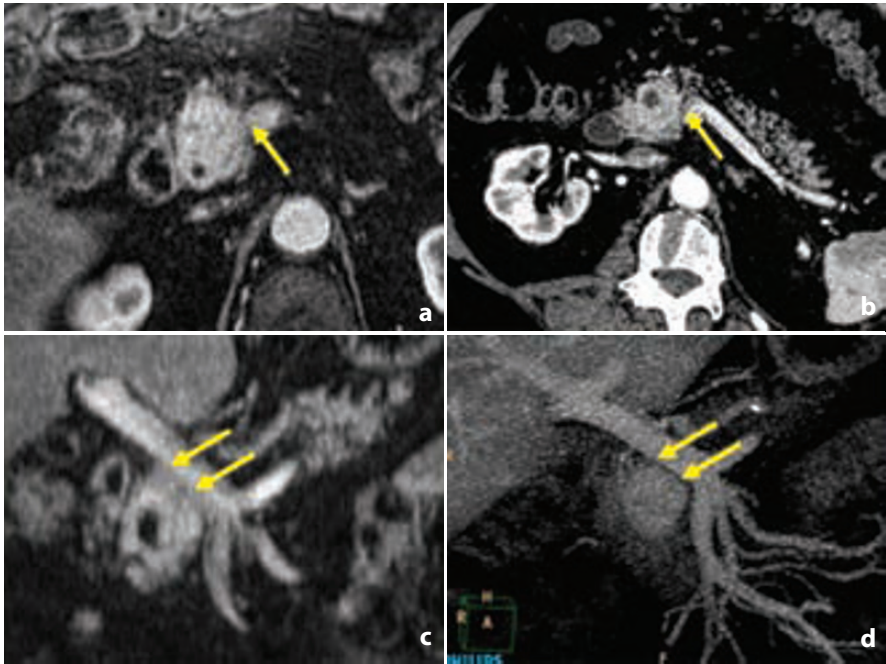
Involvement of peri-tumoral vessels, assessed using MDCT and MRI. A relatively small but inhomogeneous NF-PanNEN/C of the pancreatic head is located close to the superior mesenteric vein (*arrow*) on axial portal-enhanced MRI (a) and MDCT (b). Coronal reconstructions obtained using MRI (c) do not rule out vessel involvement (*arrows*). Conversely, MDCT (d), with its higher spatial resolution, demonstrates the presence of an adipose interface between tumor and vessel (*arrows*)
